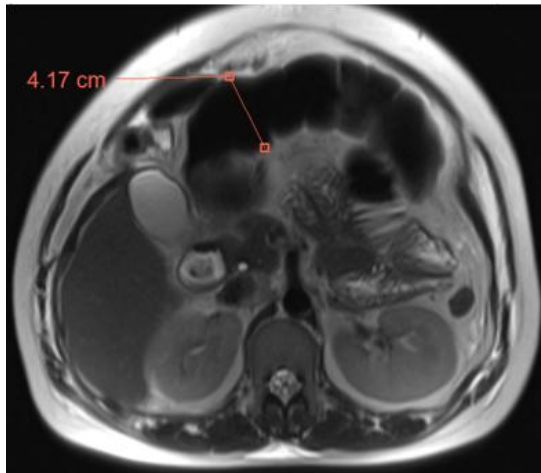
MRI showing distended small bowel loops
